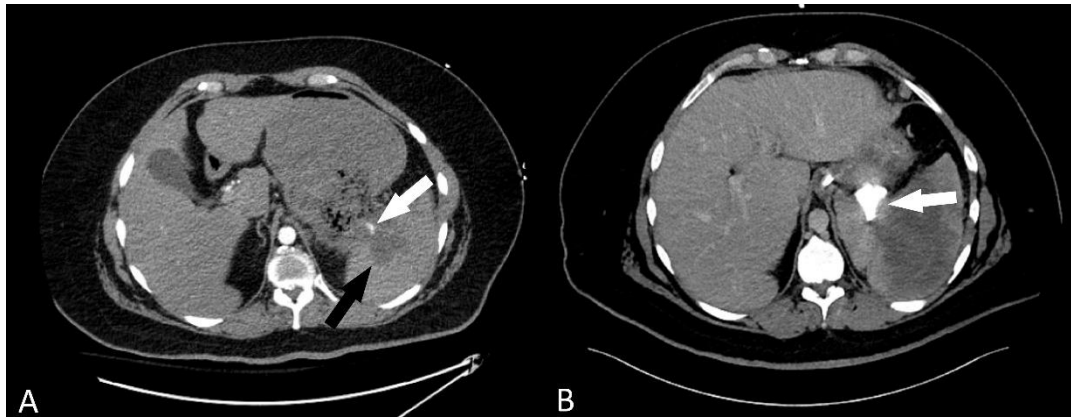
Axial image, abdominal CT angiogram (A) demonstrates a small segment of distal splenic artery (white arrow) approaching necrotic center of the spleen (black arrow).
